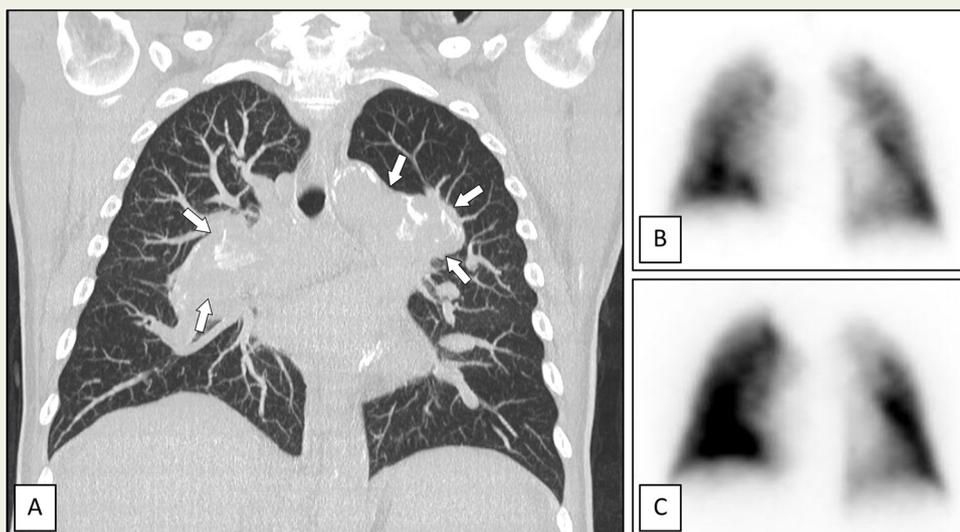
A Coronal computed tomography (CT) of the mid thorax. Unclear, partially calcified bilateral hilar enlargements (white arrows). B/C: Ventilation/perfusion scintigraphy of the lung (posterior-anterior). No evidence of pulmonary perfusion deficits.
